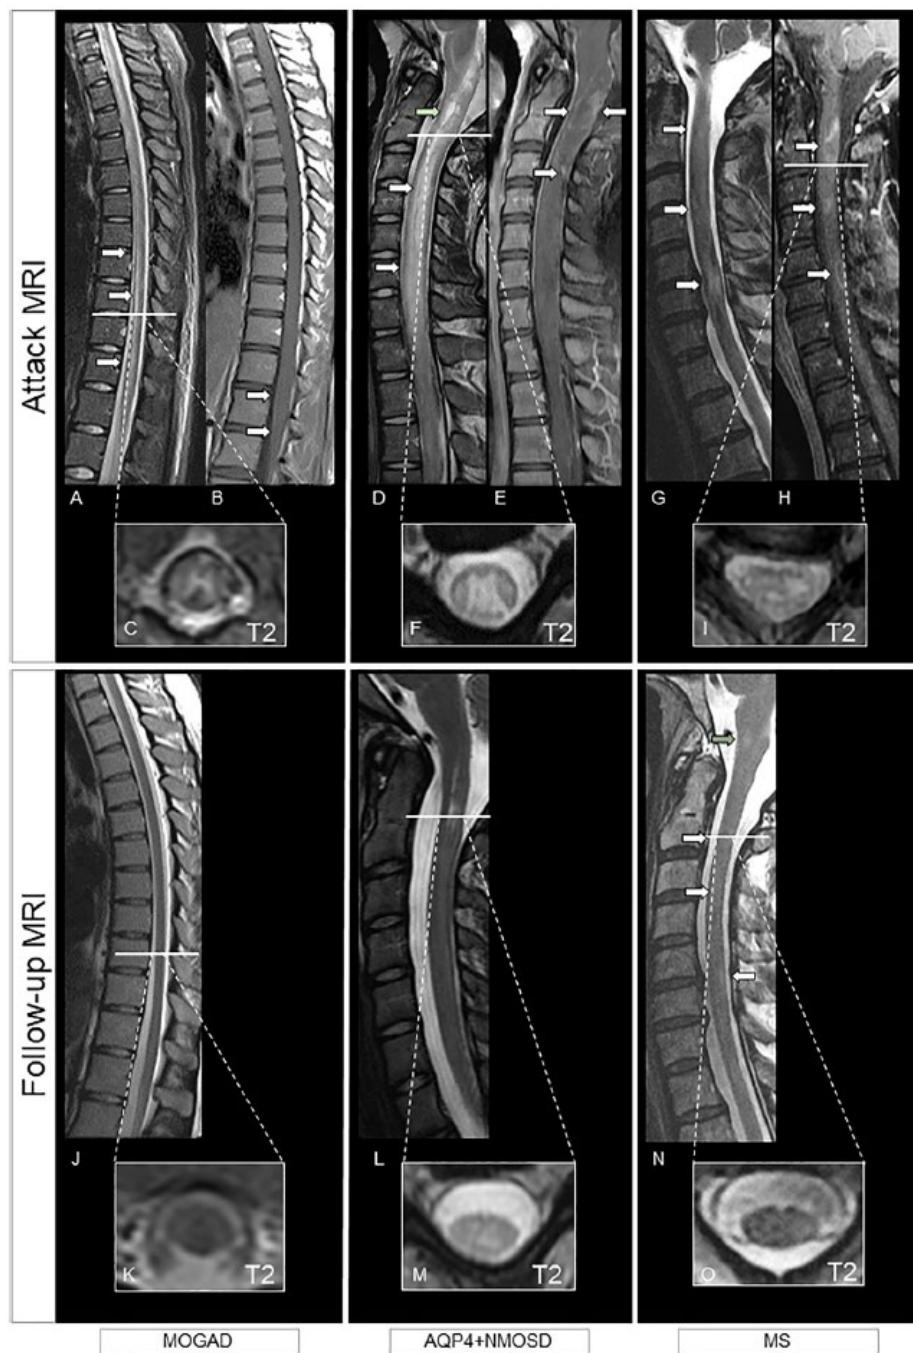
Comparison of spinal cord MRI findings in MOGAD, NMOSD, and MS [11].
